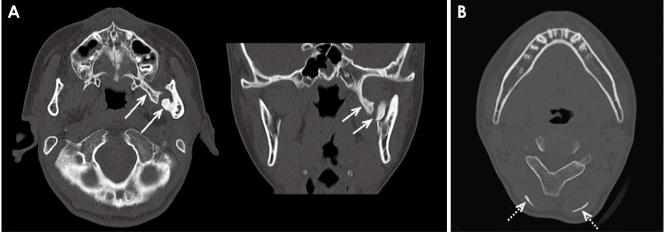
A. Axial and coronal computed tomography images display heterotopic bone formation in the left lateral pterygoid muscle, extending from the left subcondylar neck to the lateral pterygoid plate (arrow). B. An axial computed tomography image reveals sheet-like heterotopic ossification of the trapezius muscle (open arrow).
